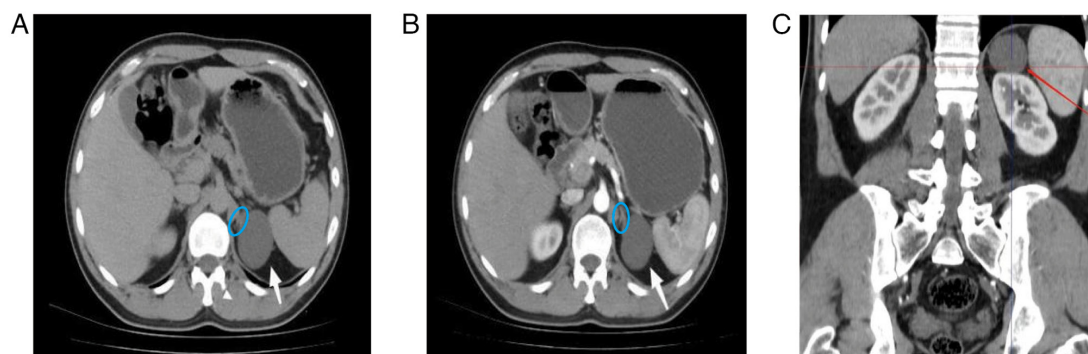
Plain and contrast-enhanced CT images of the adrenal cyst. (A) Plain CT scan showing a low-density, round mass at the junction of the left adrenal gland. The white arrow indicates the cyst. The blue oval outlines the left adrenal gland. (B) Contrast-enhanced CT during the arterial phase showing no enhancement of the cyst. The white arrow indicates the cyst. The blue oval outlines the left adrenal gland (inverted-Y shape). (C) Coronal CT reconstruction during the arterial phase showing the cyst. The red arrow indicates the adrenal cyst located at the upper pole of the left kidney.
